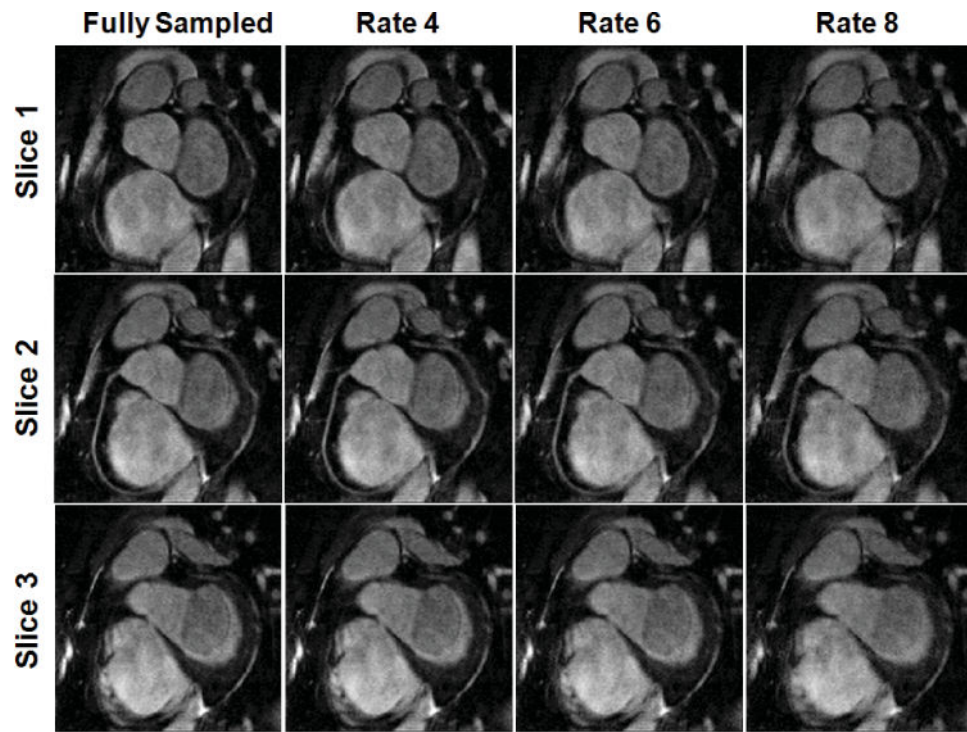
Multiple slices of a 3D coronary MR image from fully-sampled data (reference), and from reconstructions using the proposed BLS-GSM method for accelerated acquisition rates of 4, 6 and 8.
